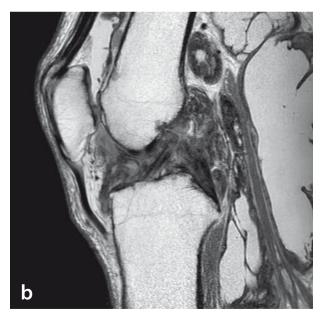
Sagittal turbo-spin echo proton density-weighted MR image presents Dt-GCT located intra- and extra-articular, posterior a large Baker's cyst including tumour involvement.
